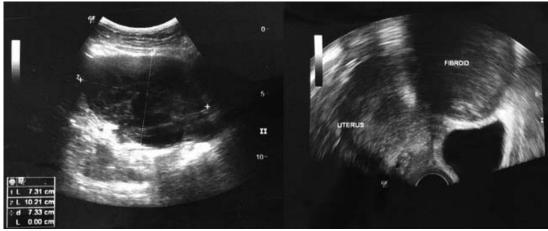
Transabdominal sonography (on the left) and transvaginal sonography (on the right) noted presence of a pelvic mass adherent to anterior uterus.
